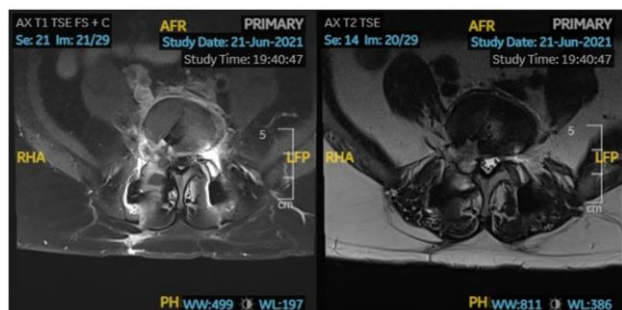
MRI images dated 6/21/21 showing spinal fusion present at L4-L5. There is edema and enhancement within L4-L5 vertebral bodies. There is also cortical irregularity involving the superior and inferior endplates at which was not present on the prior exam. In addition, there is bowing of the posterior cortex of L5 vertebral body and postoperative fluid collections involving the right side of the thecal sac with peripheral enhancement. Given the patient's history, this could represent small areas of infection and/or abscesses. The degree of bone marrow edema and enhancement likely represents osteomyelitis.
